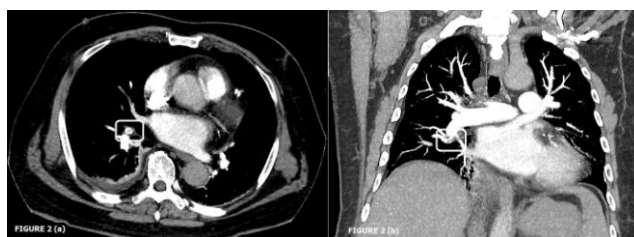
a) Computed Tomography of Pulmonary Angiography (CTPA) Axial view of the thorax showing pulmonary embolus effecting the secondary branch of descending right pulmonary artery. The partial central filling defect surrounded by contrast material produces polo mint sign, in keeping with acute embolus; b) CTPA Coronal view of the thorax shows filling defect of the right basal trunk with no extension into the right lower lobe segmental branch
